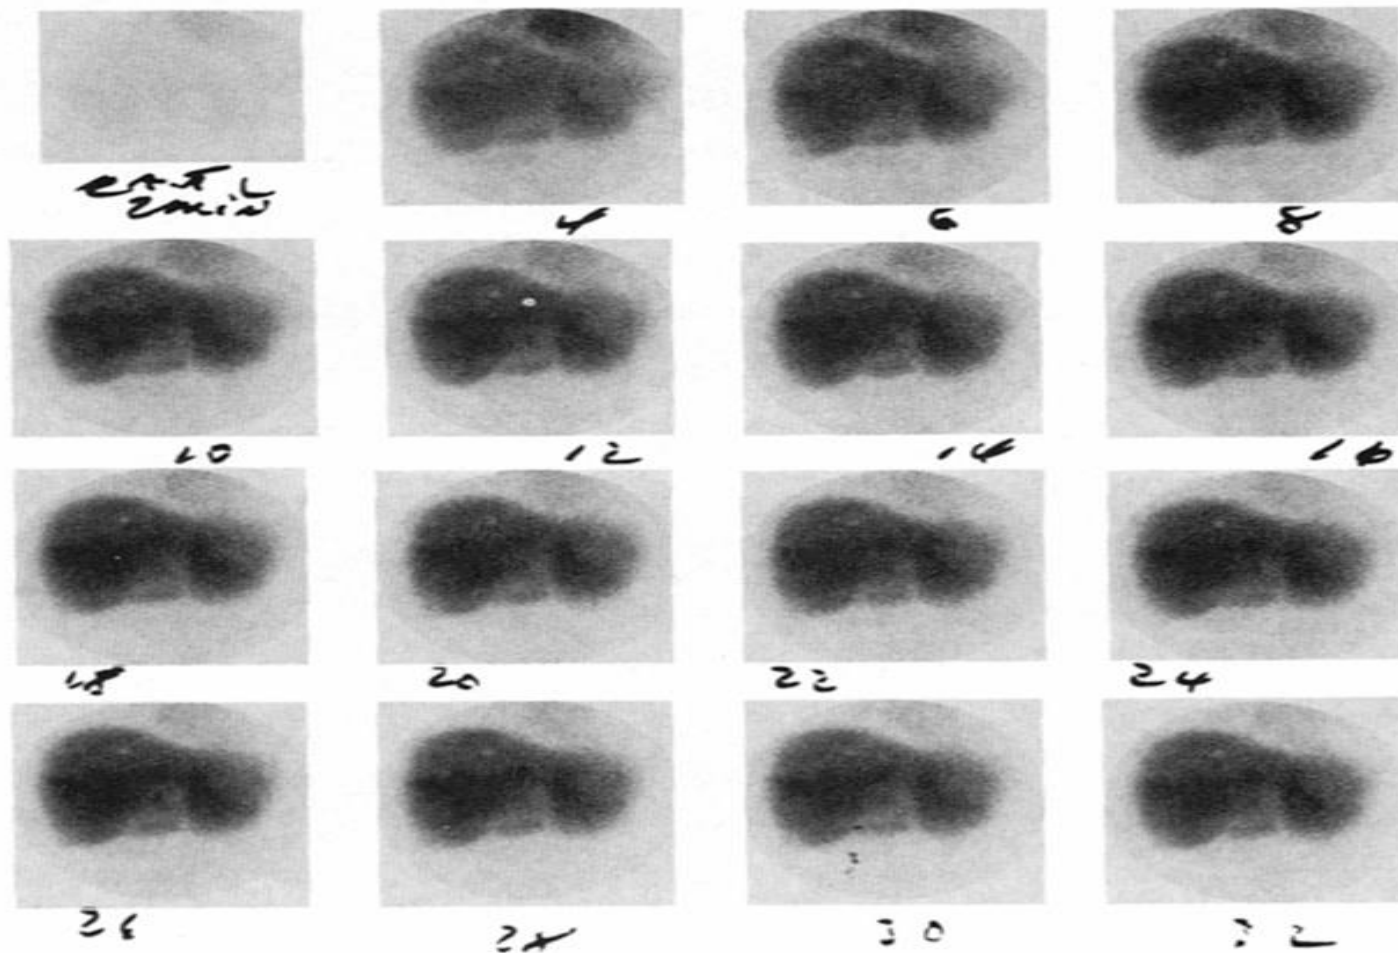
Quantitative hepatobiliary scintigraphy showing poor hepatocyte extraction fraction (HEF) and delayed $T_{1/2}$ excretion in a biopsy proven acute rejection. (Courtesy of Dr Eva Dubovsky.)
